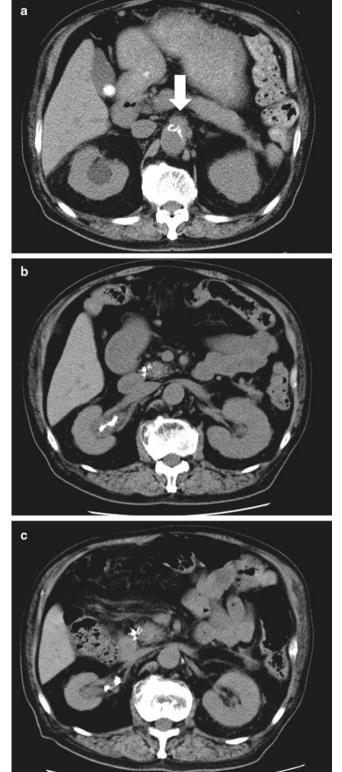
Computed tomography (CT) findings in the patient. (a) Right hydronephrosis and soft tissue-density lesions around the abdominal aorta (*arrow*) were observed on admission. (b) After ureteral stents were placed, the right hydronephrosis subsided. The left kidney was hypertrophic, whereas the right kidney was slightly atrophic. (c) At 1 month after the start of steroid treatment, both kidneys had diminished in size
